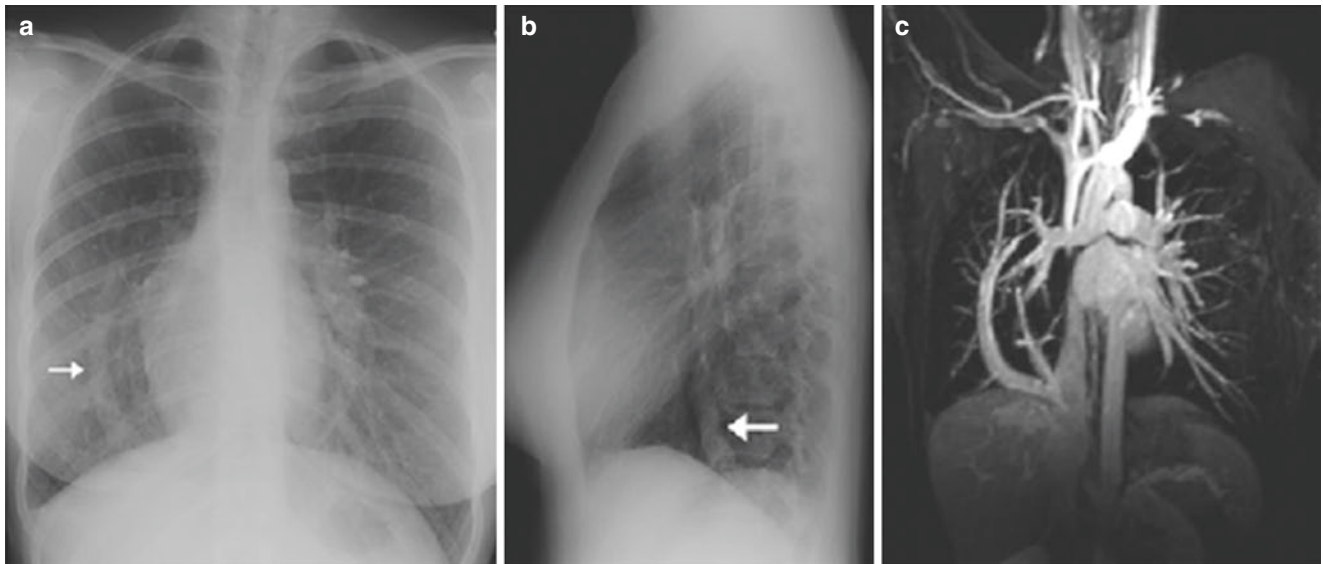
An aberrant right upper lobe pulmonary vein, a scimitar vein, is easily recognized (*arrow*). (a) PA projection. (b) Lateral projection. (c) Coronal MRI
